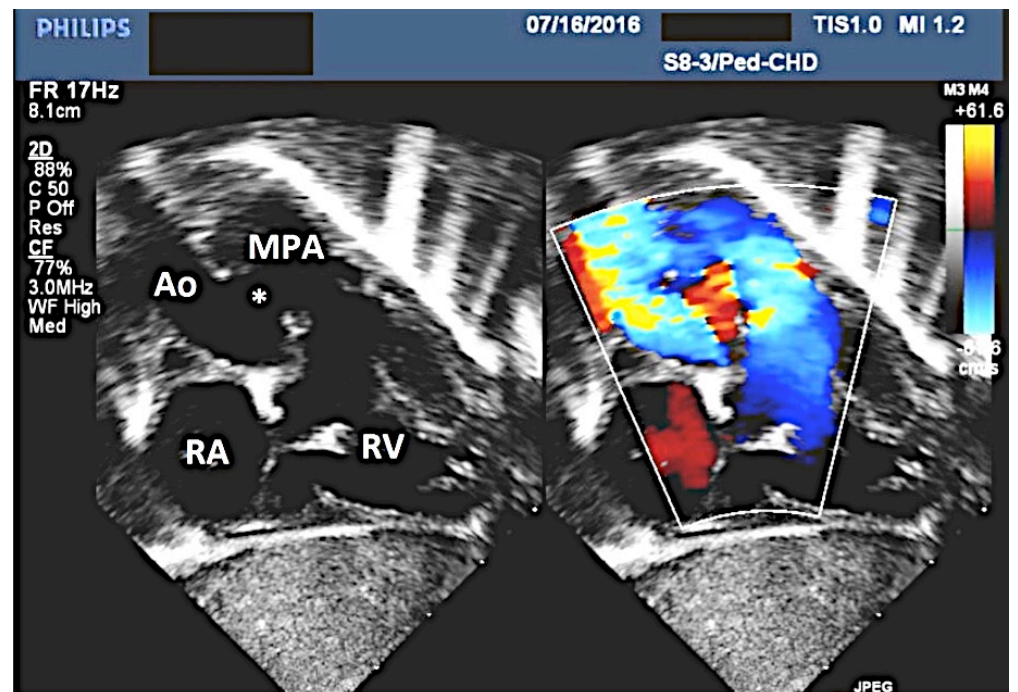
Echocardiogram image of the Aortopulmonary Window. Ao = aorta; MPA = main pulmonary artery; RA = right atrium; RV = right ventricle; * = Aortopulmonary Window.
